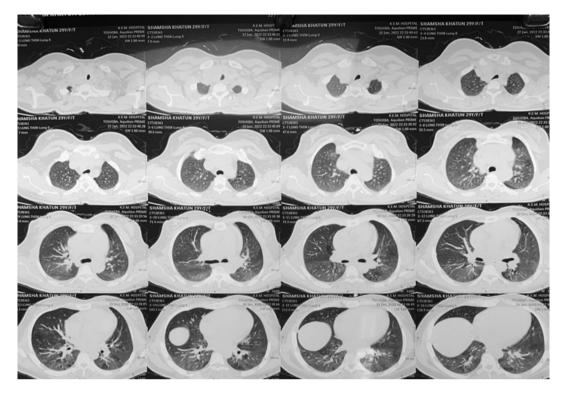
Computed tomography of the chest demonstrated a well-defined hypodense lesion in the right lobe of the thyroid, measuring 3.9 cm x4.3 cm x7.8 cm with a 1.6-inch extension into the mediastinum in the pre vascular space
